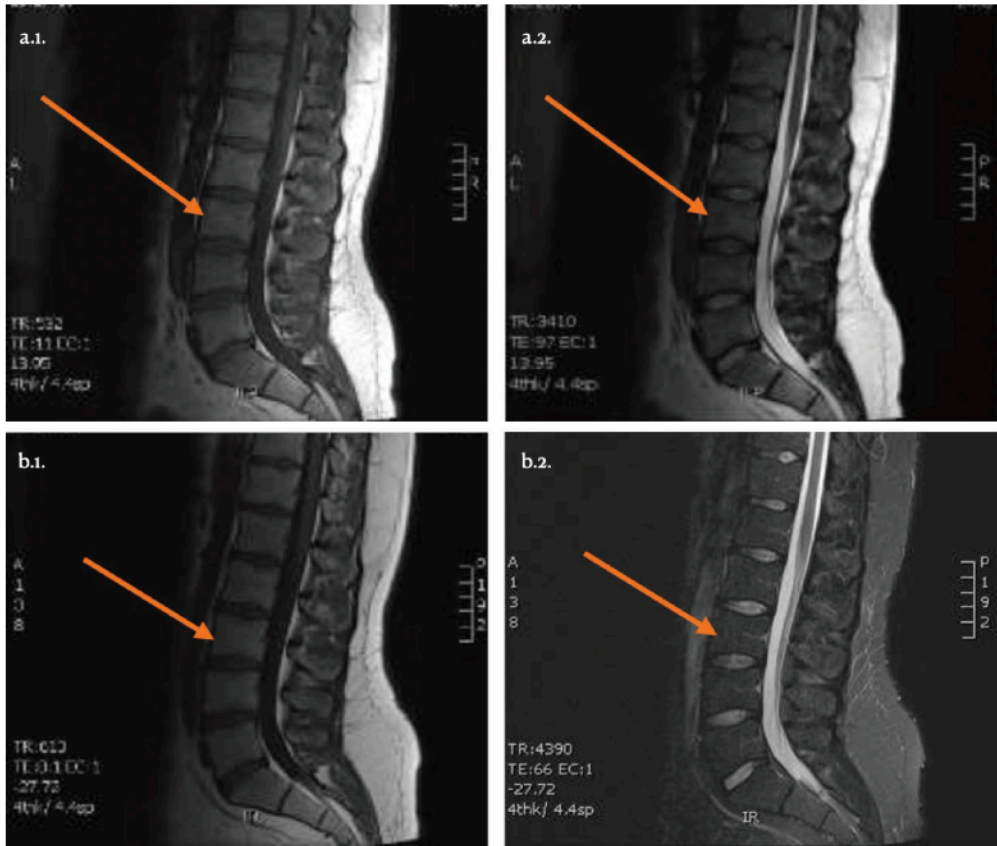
MRI sagittal sections of patient 3, before PRP injection (a.1. T1 sequence; a.2. T2 sequence) and at 12 months post-injection (b.1. T1 sequence; b.2. T2 sequence).
